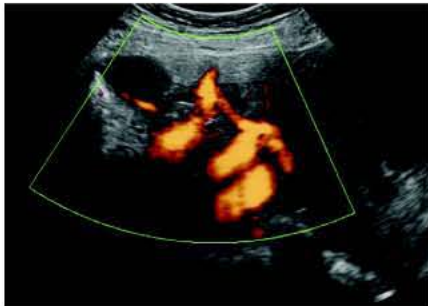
The “whirlpool sign” on colour Doppler US represents the torsed ovarian pedicle. Notice the corkscrew appearance of the vessels.
